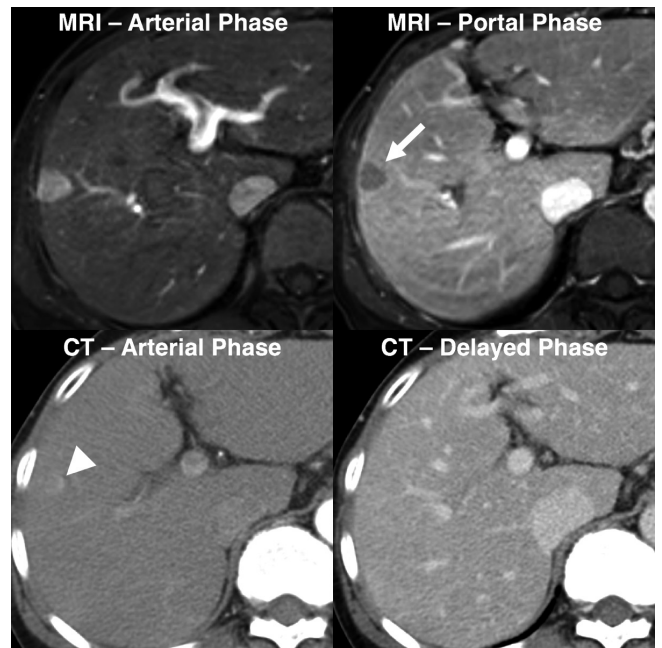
Pathologically-confirmed HCC categorized as LR-5 only with gadoxetate-enhanced MRI. 58-year-old female HBV carrier underwent both dynamic CT and gadoxetate-enhanced MRI with interval of 3 days. Her serum alpha-fetoprotein level was elevated at surveillance for HCC. On gadoxetate-enhanced MRI, all our reviewers found 1.8-cm nodule in right liver (arrow) with arterial hyperenhancement, portal washout appearance, and categorized this nodule as LR-5. However, on dynamic CT, only faint arterial hyperenhancement (arrowhead) was visualized at corresponding location. All reviewers categorized lesion as LR-3 or LR-4. HBV = hepatitis B virus
